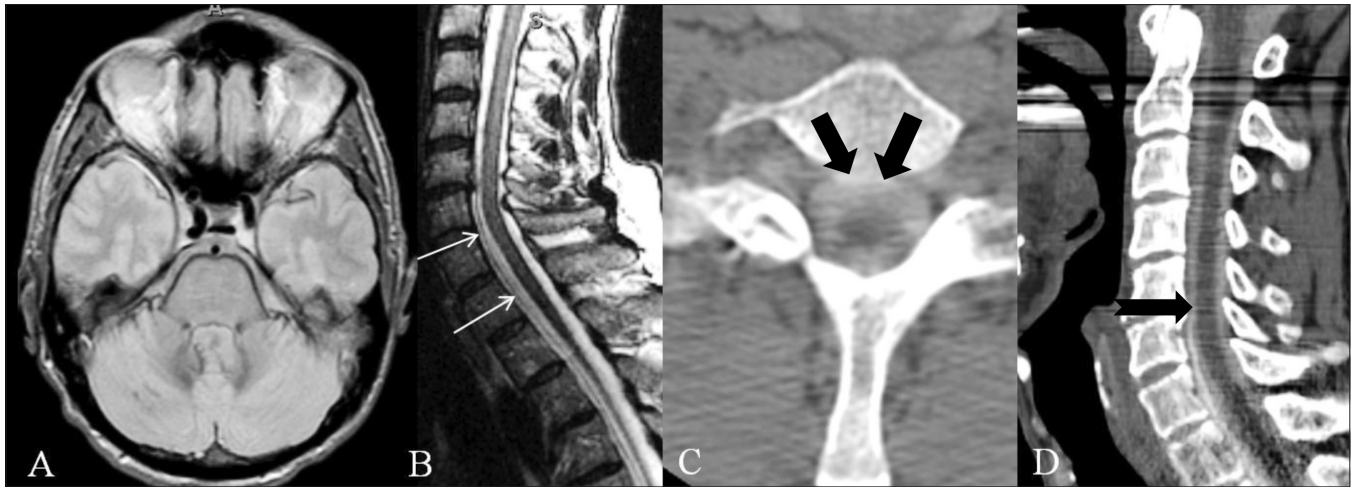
(A-D): Axial gradient-echo MRI (A) shows superficial siderosis around the cerebellar hemispheres and brainstem. (B) Sagittal T2W spine MRI shows a ventral fluid collection (thin white arrows) in the thoracic spine. Axial (C) and sagittal (D) immediate CT myelogram shows contrast pooling in the ventral collection (thick black arrows) with similar contrast density in the thecal sac and ventral fluid collection at the C₅-C₆ disc level, suggesting site of leak (notched black arrow)
